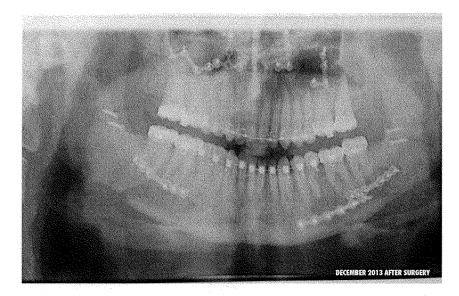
Panoramic X-Ray taken in December following the Orthognathic Surgery performed on August 16, 2013. Note the fracture, on the lower left, open (not healing) and the large amount of hardware in both the upper and lower jaw. Mr. LaBonte was not made aware that such a large amount of hardware was going to be used in this surgery or the possible health risks involving this hardware. Increased risk of infection, improper healing, auto-immune system response to foreign bodies which includes a wide range of symptoms, possible nerve compression/damage due to misplacement of hardware, possible bone death due to hardware cutting off blood supply to certain parts of jaw, tooth root damage due to screws from hardware, among many other negative side effects.
